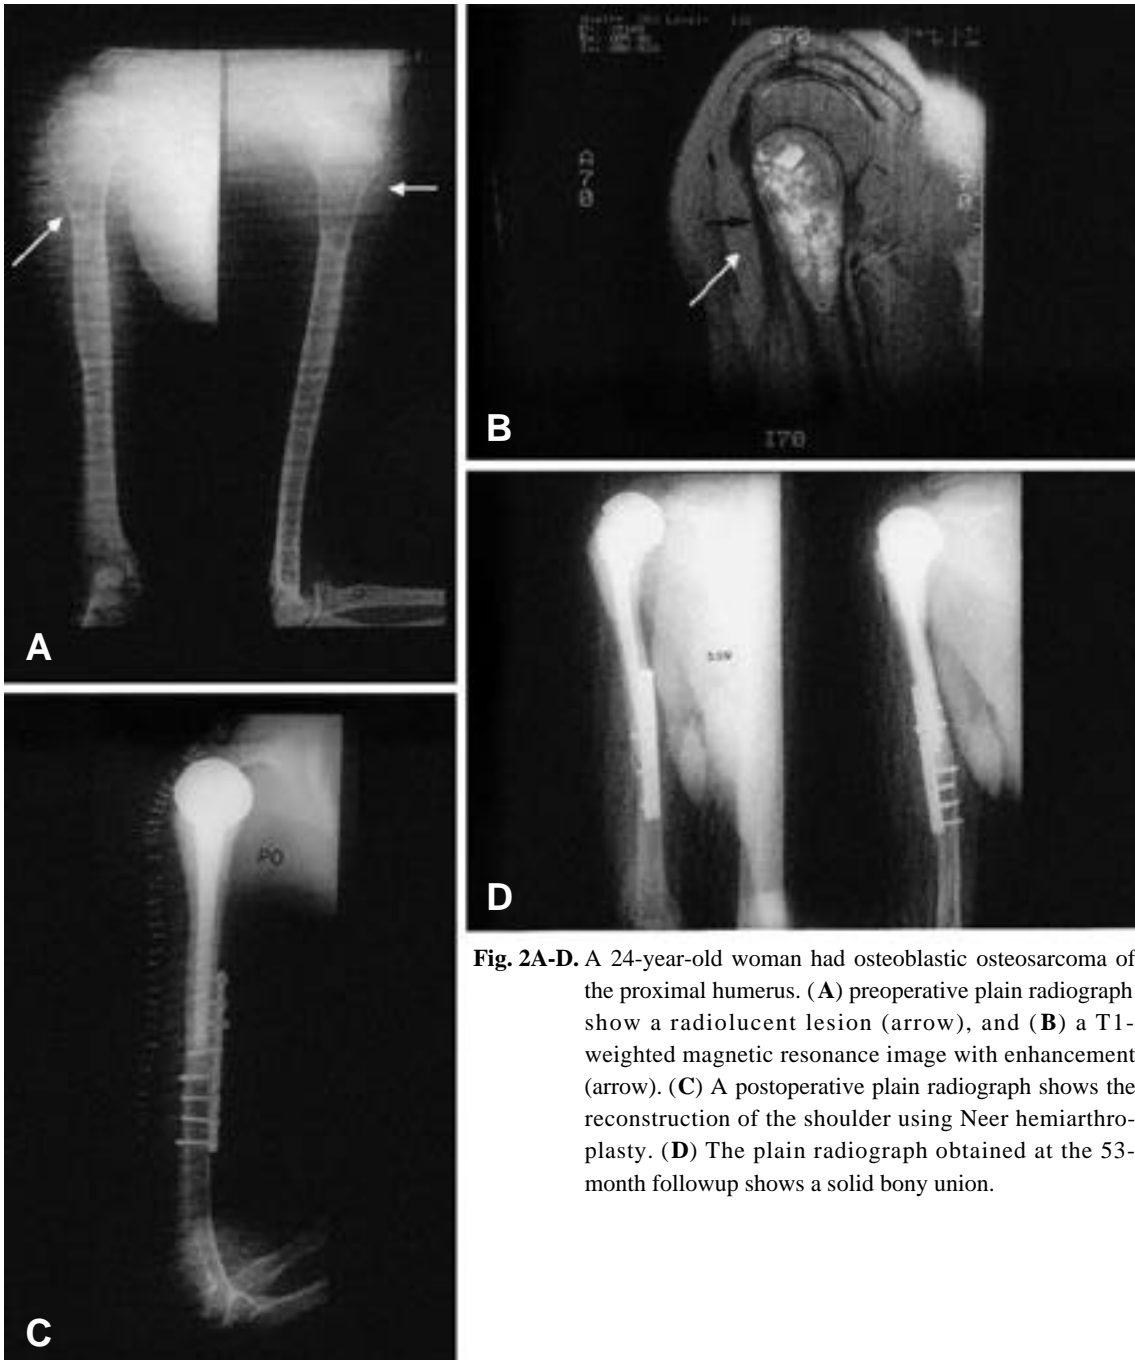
A 24-year-old woman had osteoblastic osteosarcoma of the proximal humerus. (A) preoperative plain radiograph show a radiolucent lesion (arrow), and (B) a T1-weighted magnetic resonance image with enhancement (arrow). (C) A postoperative plain radiograph shows the reconstruction of the shoulder using Neer hemiarthroplasty. (D) The plain radiograph obtained at the 53-month followup shows a solid bony union.
